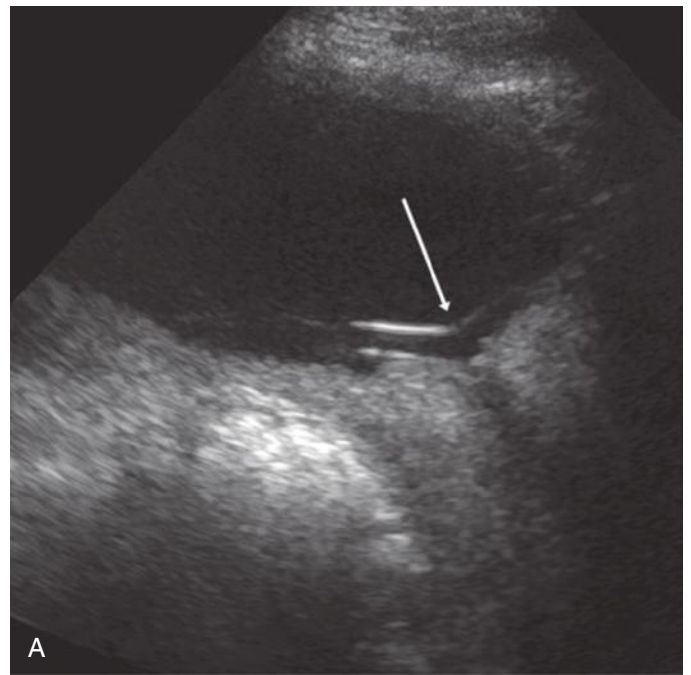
Vasa previa. A, A tubular structure (arrow) is shown overlying the cervix on this transabdominal sagittal sonographic image. B, With color and spectral duplex Doppler interrogation, this structure is shown to be a fetal vessel, confirming vasa previa. In many instances, the unprotected fetal vessel crossing the cervix is not appreciated on gray-scale images and is only detected with careful Doppler evaluation.
